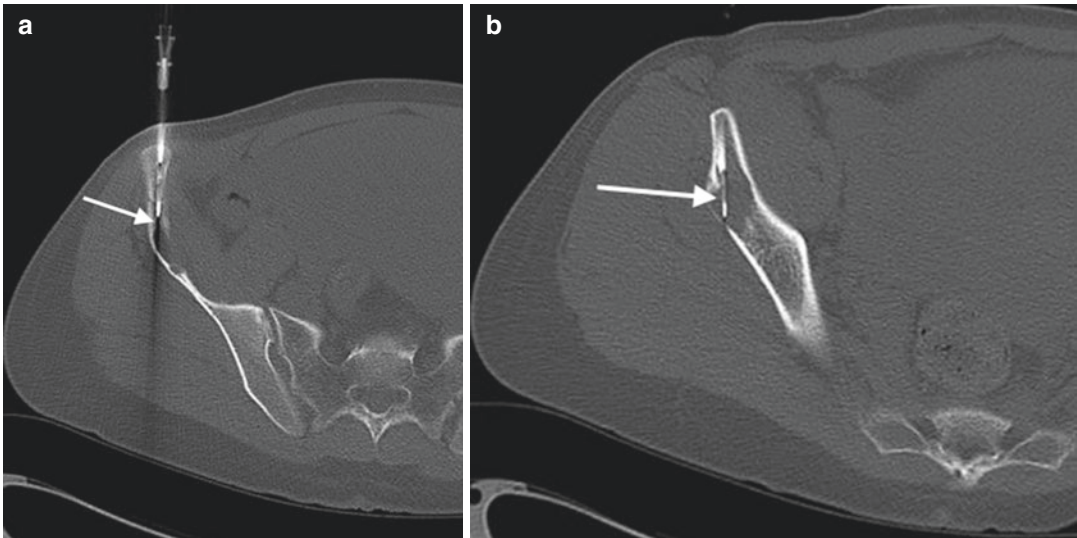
Biopsy complication: broken needle. Axial CT image (a) shows guide cannula in place within the iliac crest. An attempt was made to biopsy the lytic lesion (arrow) with a soft tissue core biopsy needle. Axial CT
